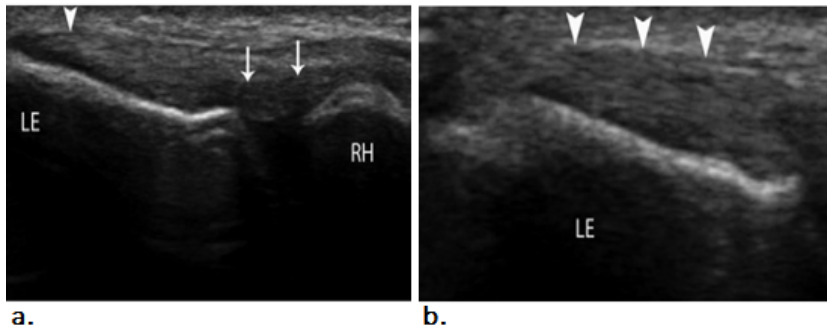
Ultrasound (US) of a normal common extensor tendon, (a) longitudinal and (b) short axis. Arrows in a = normal RCL, arrow heads in a and b = common extensor tendon. LE = lateral epicondyle, RH = radial head. Taken from Konin et al., 2013.
